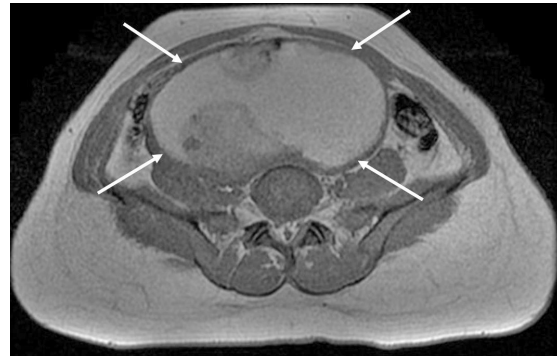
Contrast-enhanced axial T1-W MR image of the pelvis, performed through the pelvic mass (white arrows), superior to the level of the anteverted uterus.
